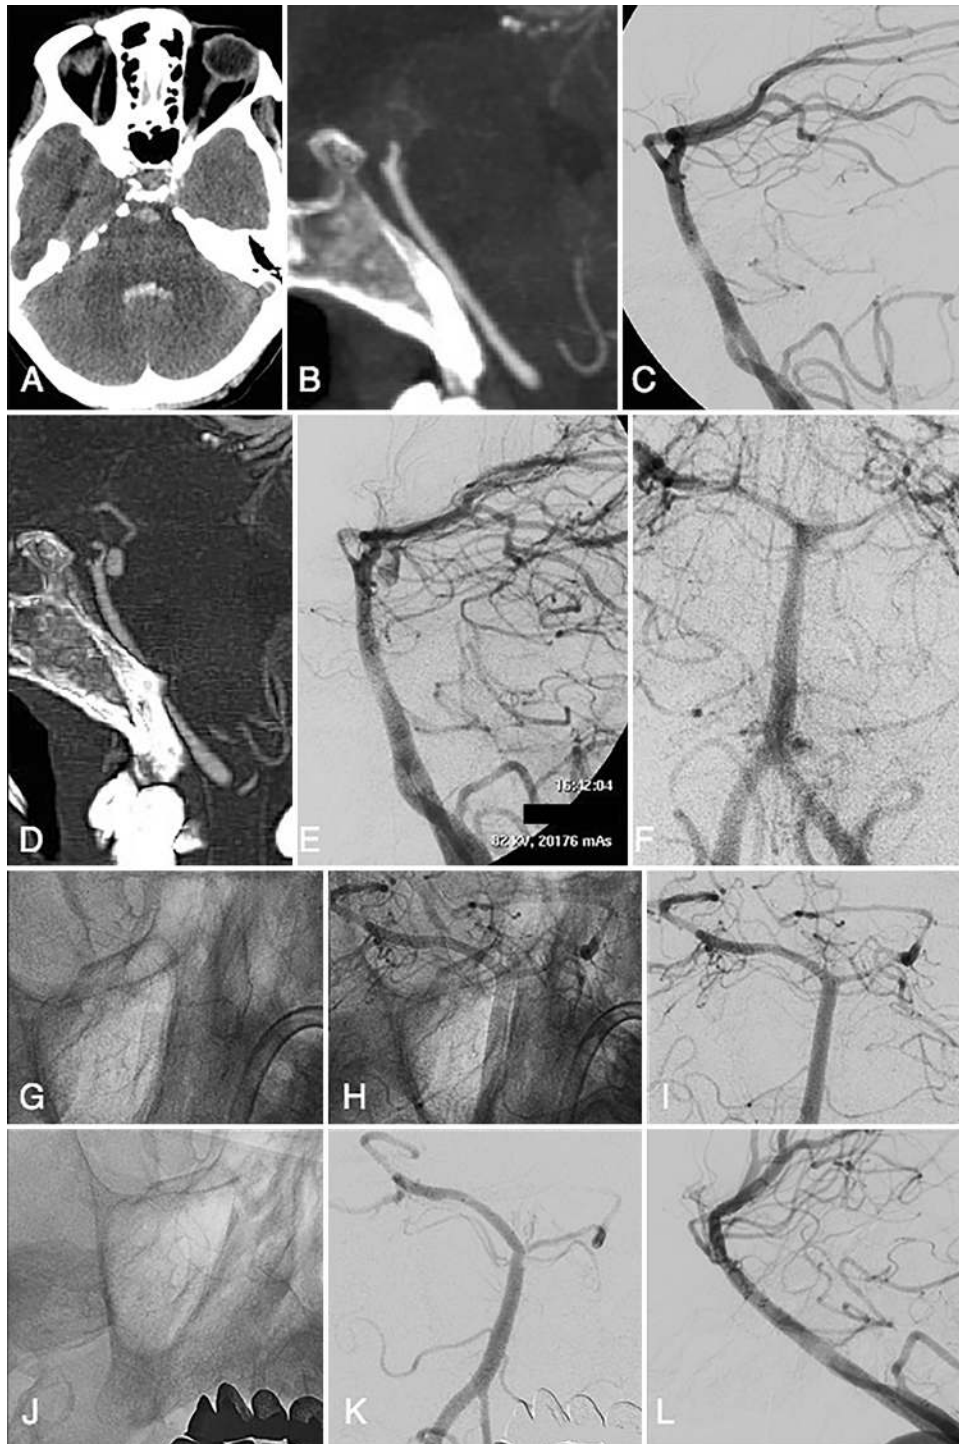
Case 11. Images obtained in a 60-year-old woman with sudden onset of headache and confusion. An unenhanced axial CT scan (A) showed SAH in the prepontine cisterns, basal cisterns, and fourth ventricle. No source of bleeding was detected on CT angiography (B) and DSA (C). A CT angiogram (D) acquired 10 days later showed a small aneurysm located on the posterior aspect of the basilar apex. Lateral and frontal angiograms (E and F) confirmed the presence of a small pseudoaneurysm of a perforator of the basilar artery that was subsequently treated via implantation of a PED from the right PCA to the mid-third of the basilar artery. Postprocedure frontal angiograms (G–I) showed good positioning of the PED with a reduction of flow inside the pseudoaneurysm. Six-month DSA follow-up (J–L) showed the disappearance of the pseudoaneurysm.
